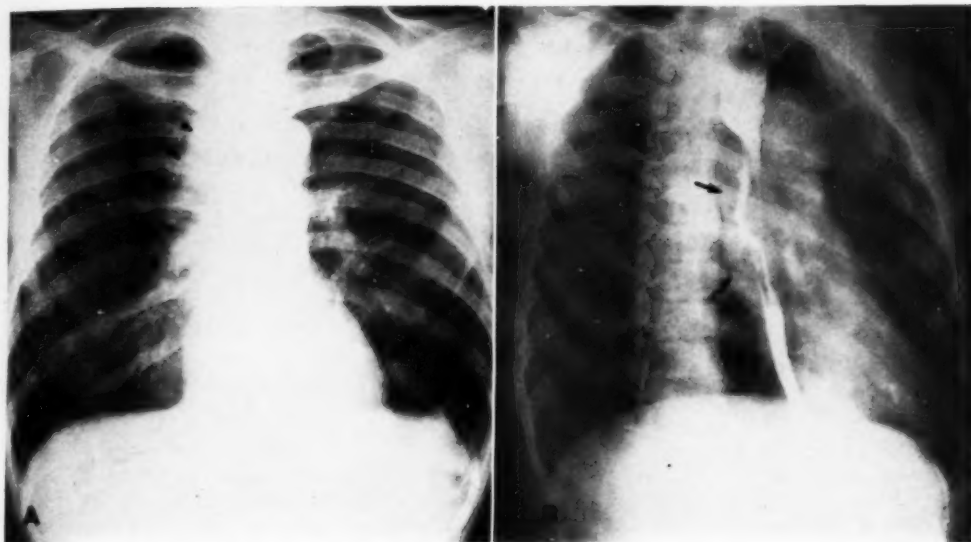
Nodes of the right pulmonary root and right paratracheal chain. A 50-year-old colored male had experienced dysphagia for the preceding three weeks. A *barium swallow* disclosed the presence of an ulcerating, constricting lesion in the mid-esophagus extending from the level of the superior margin of the aortic arch downward for a distance of 10 cm. The primary tumor (solid arrows) is best shown in the right anterior oblique view (B). On the postero-anterior roentgenogram (A) enlarged lymph nodes (dotted arrows) are seen adjacent to the right side of the trachea and at the superior margin of the right pulmonary artery.
